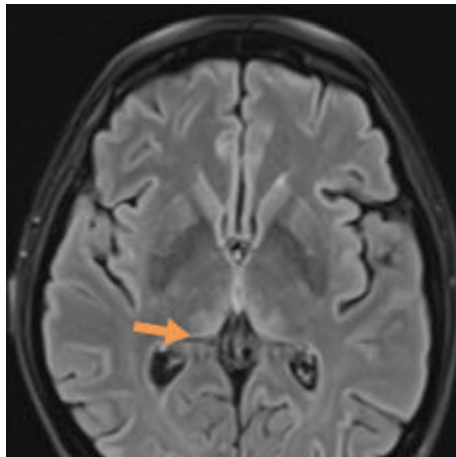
Presentation of reduction of hypersignal changes of bilateral thalamic regions on T2 FLAIR on MRI.
